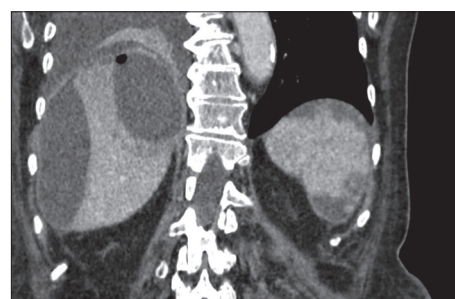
Postoperative computed tomography scan in the coronal plane demonstrating pleural effusion, fluid collection in the right subphrenic space, and viscous fluid collection in segment VI of the liver
